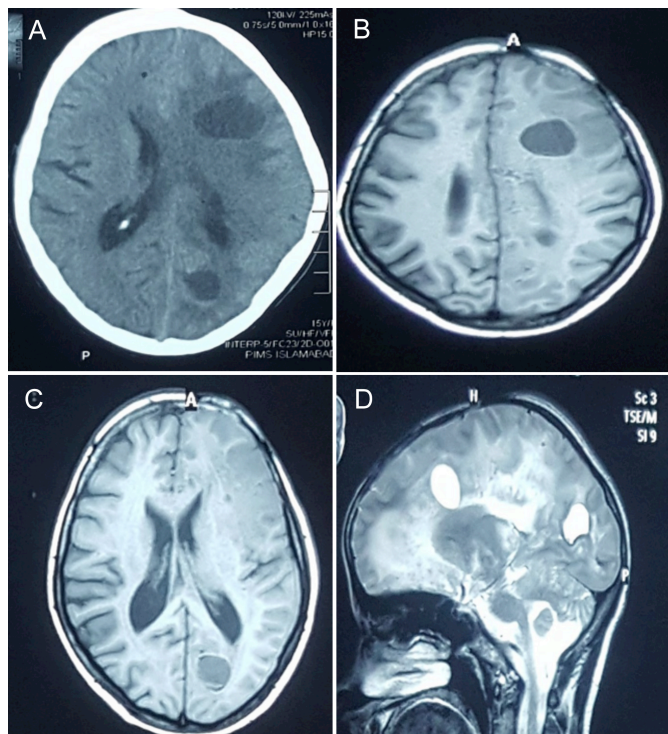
(A) Axial CT brain: Two cystic lesions with CSF density and left frontal lobe white matter hypodensity. (B) AND (C) Axial T1-weighted MRI showing left-sided CSF intensity cystic lesions and marrow fat thinning inside skull diploe. (D) Sagittal T2-weighted MRI showing left-sided two cystic lesions.
